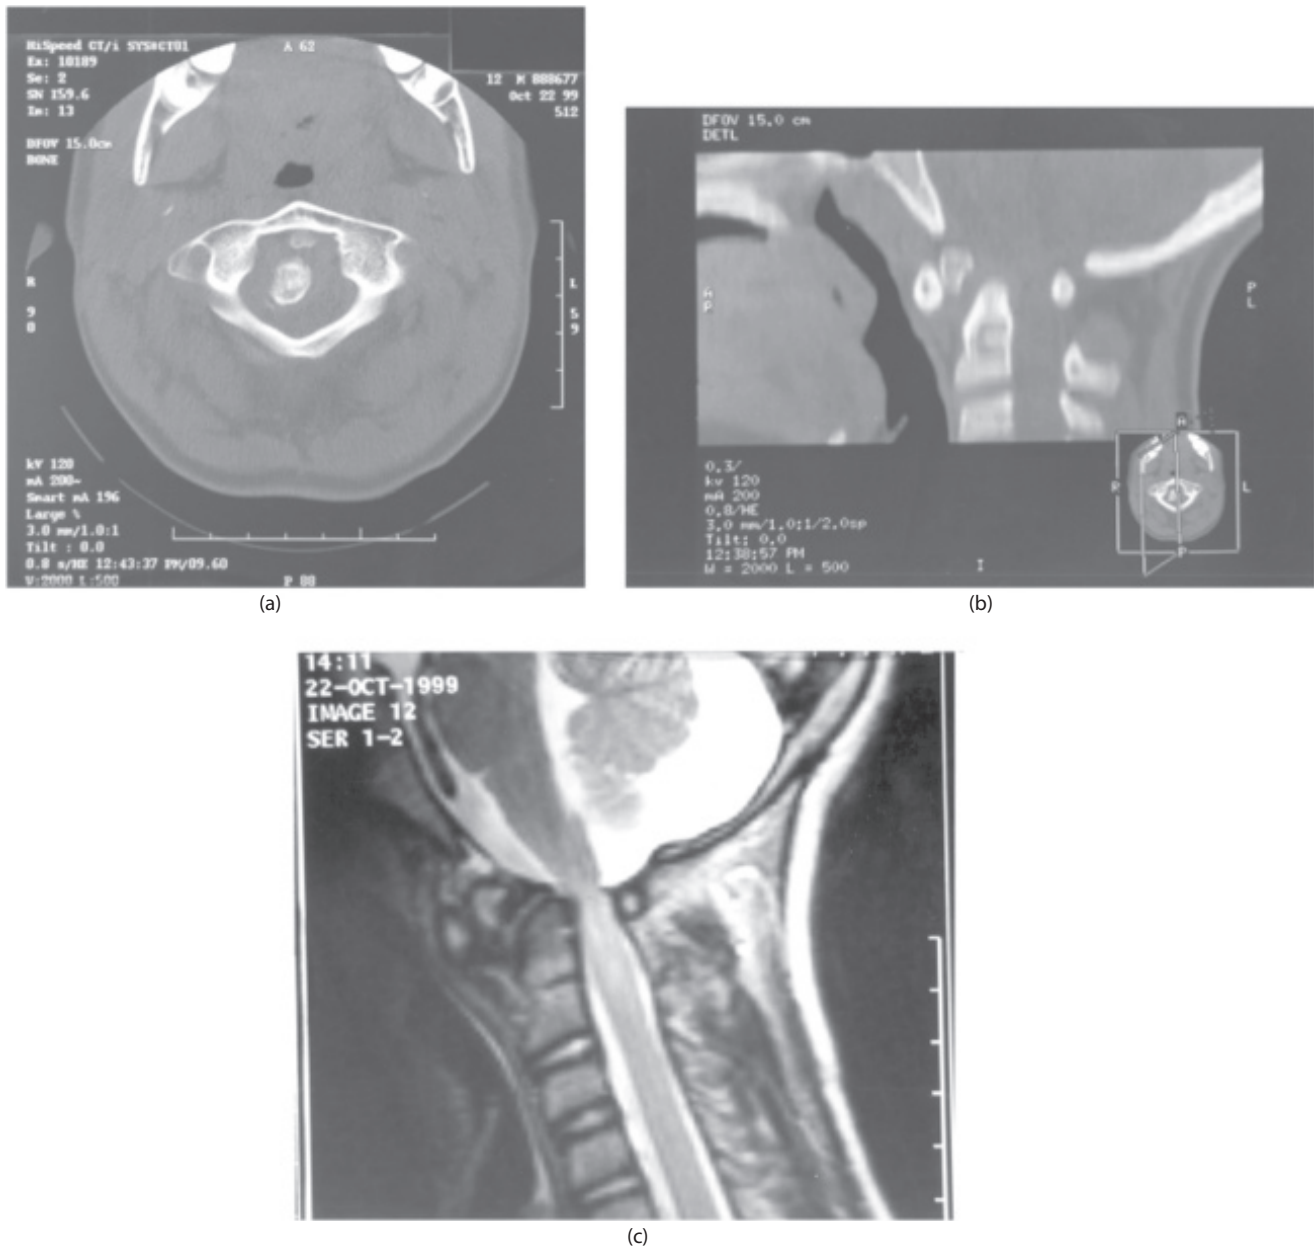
A 12-year-old with a trampoline injury and neck pain. (a) Computed tomography showed fracture of superior aspect of odontoid. (b) The 1-cm fragment was displaced anterior and inferior. (c) Magnetic resonance imaging revealed severe central canal stenosis at the cervical-medullary junction and edema within the cervical cord at the C2 and C3 levels. In addition, distension of the cerebrospinal fluid spaces within the posterior fossa was evident, likely due to the degree of stenosis.
